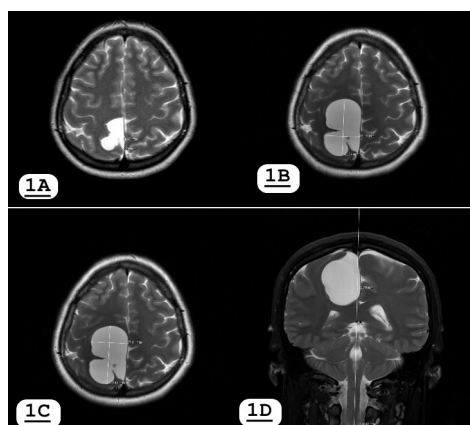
In the images, the arachnoid cyst image of the patient at the time of initial diagnosis (1A), the image with increased size during follow-up (1B), and the image taken after acetazolamide treatment (1C and 1D) are shown in T2-weighted MR images
